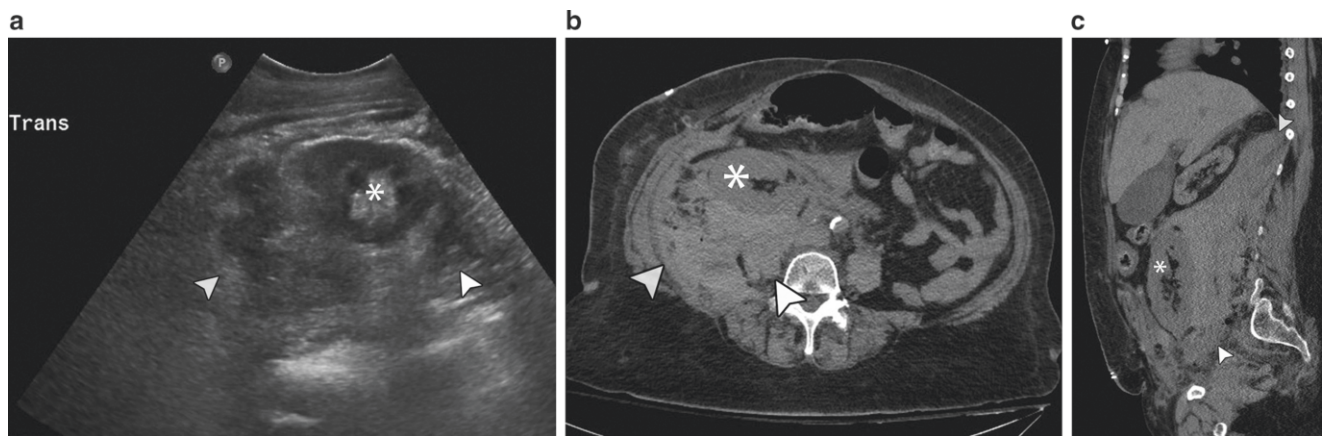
Hematoma. (a) Ultrasound shows a complex perinephric hematoma (arrowheads) surrounding the transplant (asterisk). Axial (b) and sagittal (c) CT performed without oral or intravenous contrast
